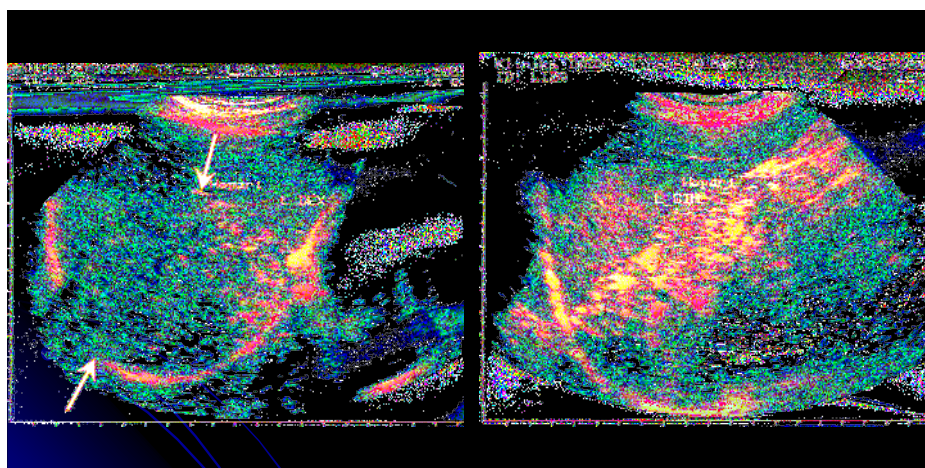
Ultrasound images of *Echinococcus* in advanced stages where calcification is recorded inside the cyst turned in hyperechogen formation as a result of the organization of Cystic content.
